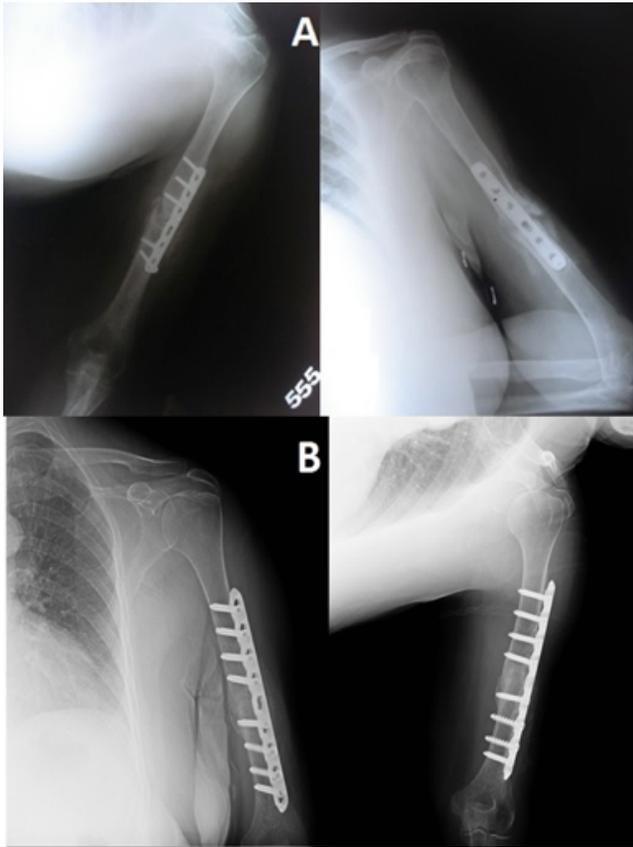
Images of a 69-year-old female patient who had undergone surgical intervention using the plate-screw system. (A) Anteroposterior and lateral radiographs taken six months after the primary surgery show the nonunion and loosening of the screws. (B) Radiological union was achieved in this patient 13 weeks after our surgical intervention with LCP fixation and autografting.
